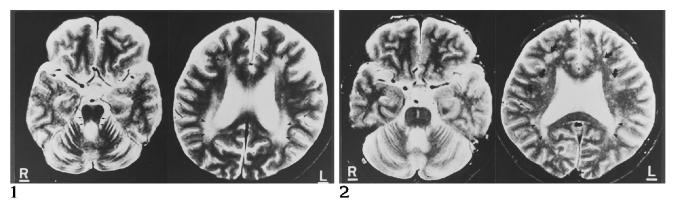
Patient 1. T2-weighted spin-echo MR sequence (3000/80/1 [repetition time/echo time/excitations]). *Left*, transaxial image through the level of superior pons shows severe brain atrophy, especially of the pontine tegmentum (*arrows*) and cerebellum. *Right*, transaxial image through the level of the body of the lateral ventricle shows cerebral atrophy predominant in the frontal lobes and diffuse periventricular hyperintensity (*arrowheads*).
